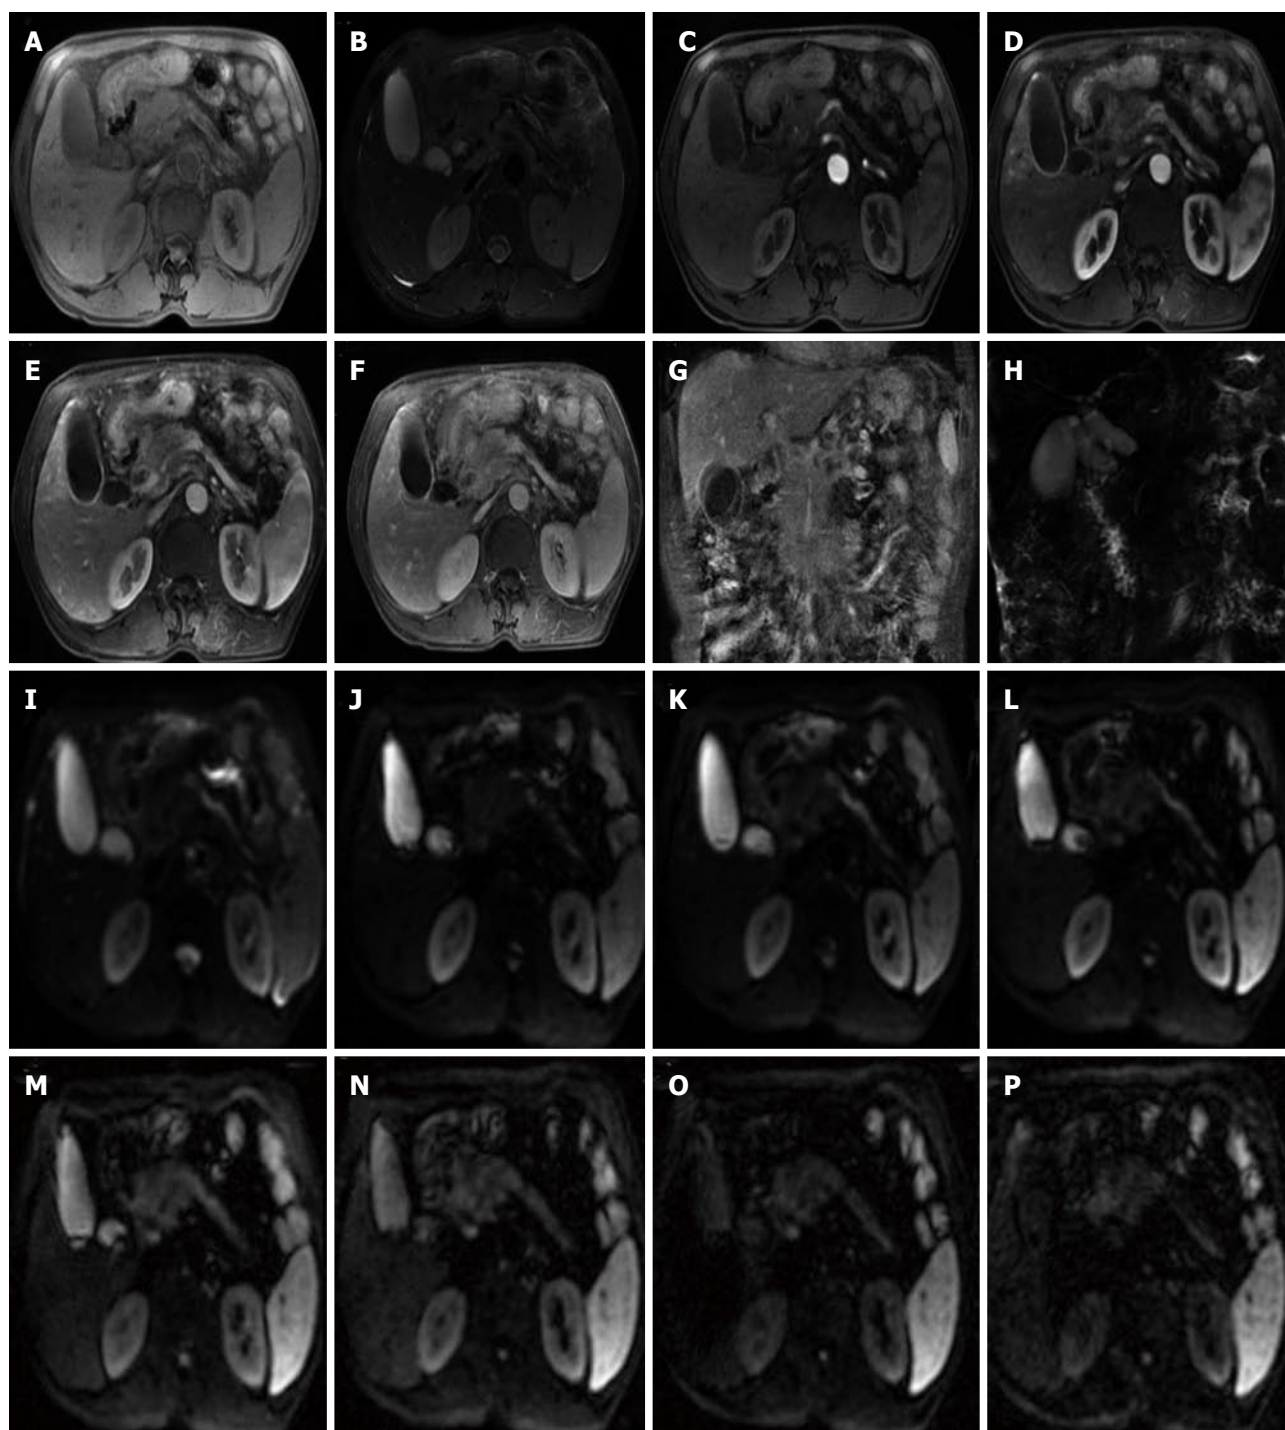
Images in a 63-year-old man with a focal lesion in the head of the pancreas. MR imaging suggests that it is a malignancy. A: Axial T1-weighted fat-suppressed gradient-echo MR image; B: Axial T2-weighted fat-suppressed fast spin-echo MR image; C-G: Axial and coronal slab three-dimensional liver acquisition with volume acceleration dynamic contrast-enhanced; H: MRCP shows the biliary obstruction; I-P: Multi-b DWI imaging ($b = 0, 50, 100, 300, 500, 800, 1000$ and 1500). MR: Magnetic resonance; DWI: Diffusion weighted imaging; MRCP: Magnetic resonance cholangiopancreatography.
